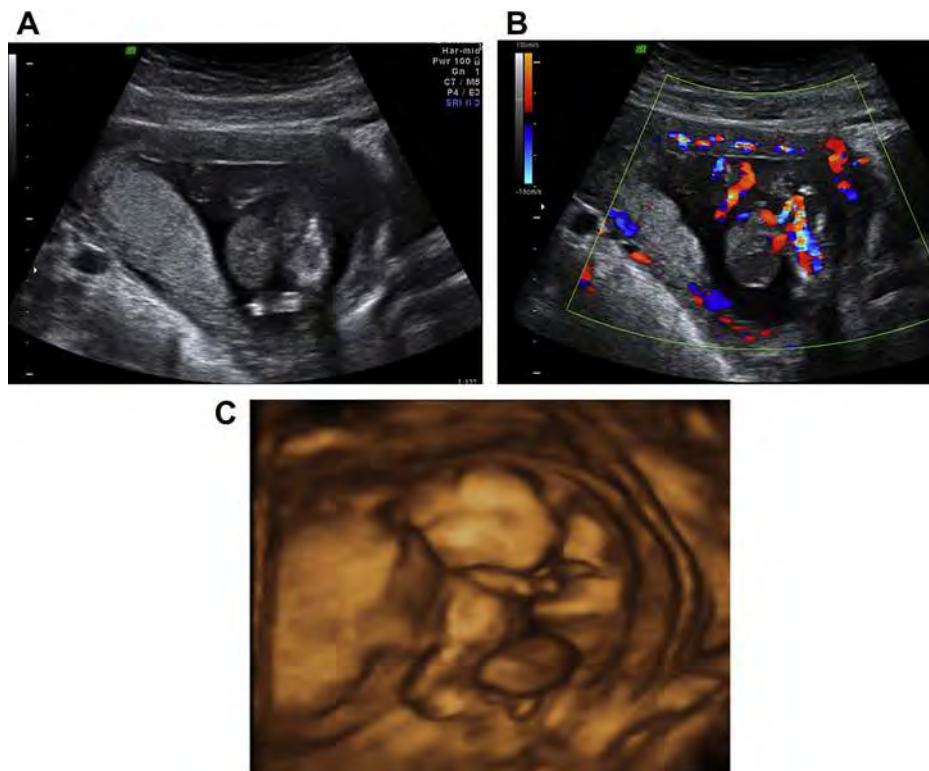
The fetal omphalocele at 13 weeks of gestation depicted by using the surface rendering mode of three-dimensional (3D) ultrasound. (A) The omphalocele on two-dimensional (2D) ultrasound image; (B) the omphalocele on color Doppler image; and (C) the omphalocele on 3D ultrasound image, using the surface rendering mode.
